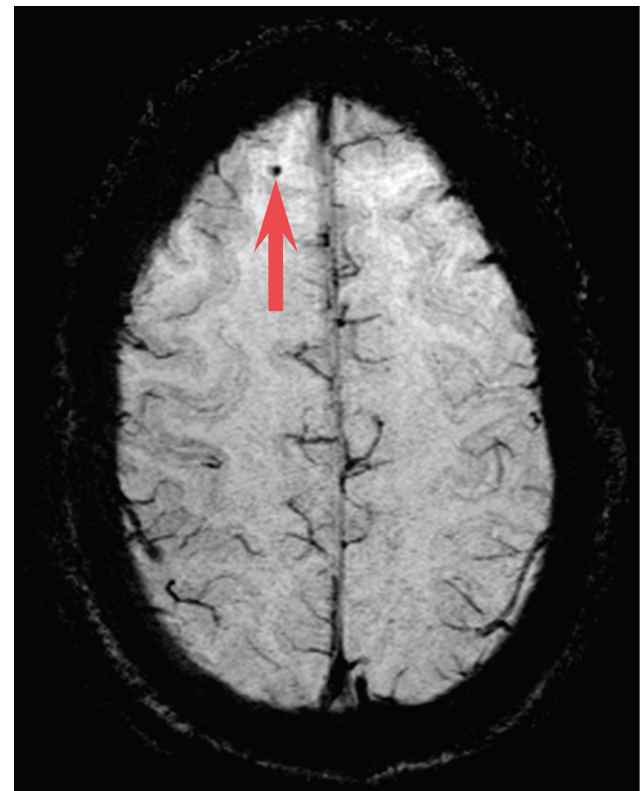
A 45-year-old former football player with a history of multiple prior concussions. Axial susceptibility weighted imaging minimum intensity projection image reveals a small focus of susceptibility artifact in the anterior right frontal lobe (arrow), consistent with prior microhemorrhage. Other routinely obtained magnetic resonance imaging sequences in this patient revealed no other structural or anatomical abnormality.
